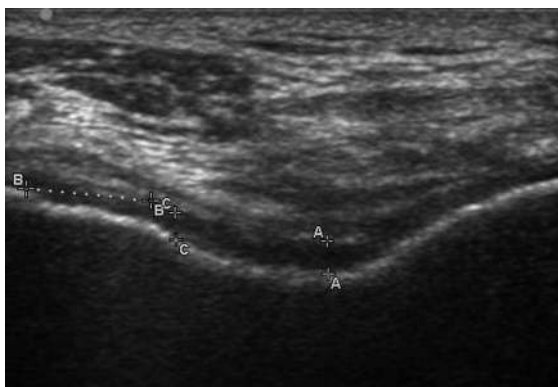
Knee cartilage measurement with ultrasound preinjection in an 87-yr-old man.
